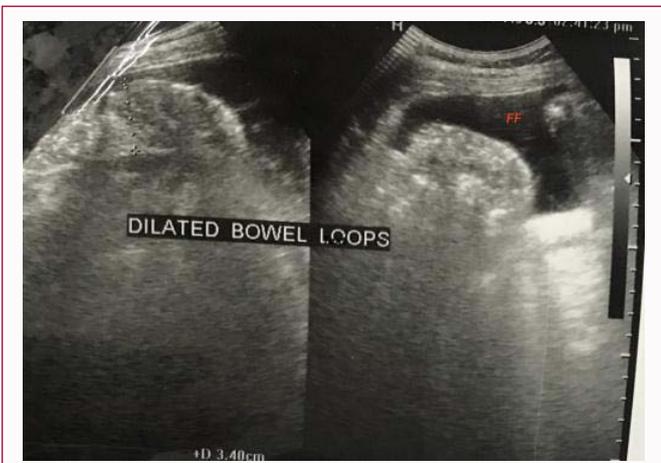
Transabdominal ultrasound showing dilated bowel loops and a small amount of free fluid (FF: Free Fluid).
